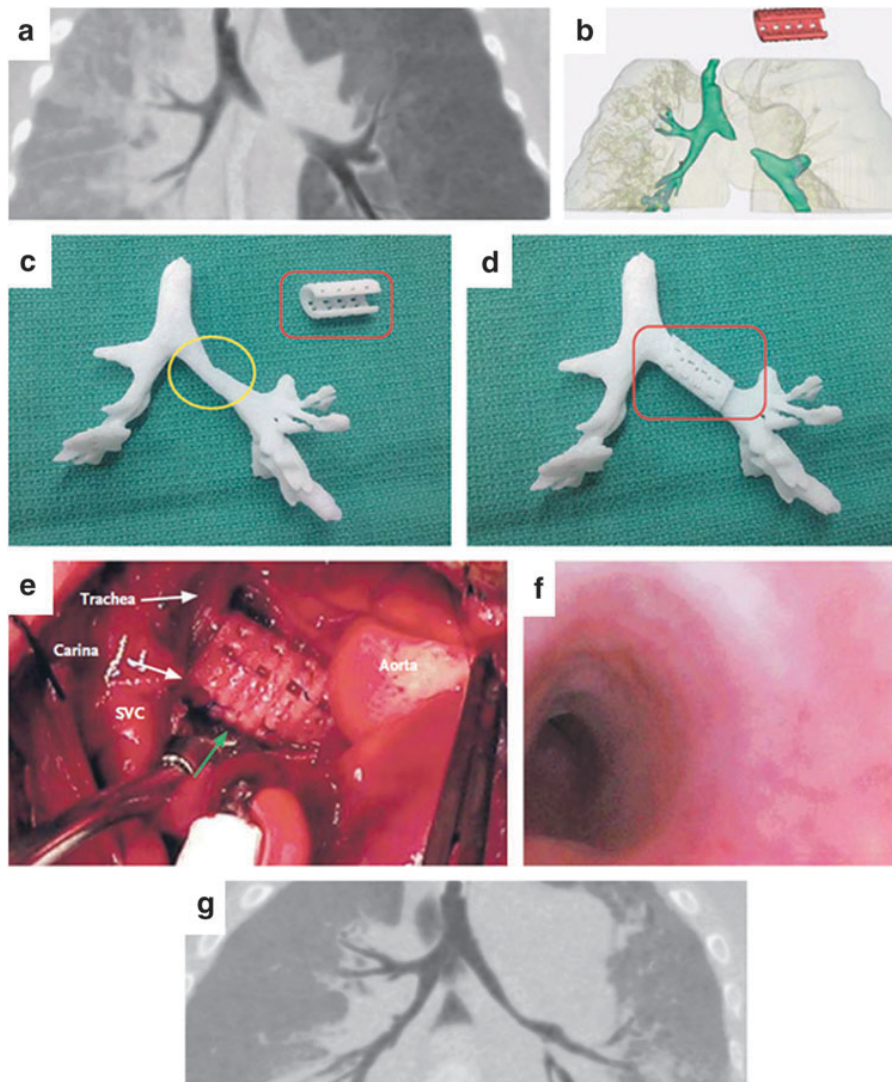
A 3D printed bioresorbable airway (adapted from Schwartz *et al.*⁹³© 2013 Massachusetts Medical Society. Reprinted with permission from Massachusetts Medical Society). (a) The airway in expiration before splint placement. (b) The patient-specific computed tomography-based design of the splint (red). (c) Image-based three-dimensional (3D) printed cast of the airway without the splint in place. (d) Image-based 3D-printed cast of the airway with the splint in place. (e) Intraoperative photograph of the splint *in situ* (green arrow) overlying the narrowed left mainstem bronchial segment. SVC denotes superior vena cava. (f) Bronchoscopic view of the left mainstem bronchus following splint placement. (g) The patent airway in expiration 1 year after the placement of the splint.
